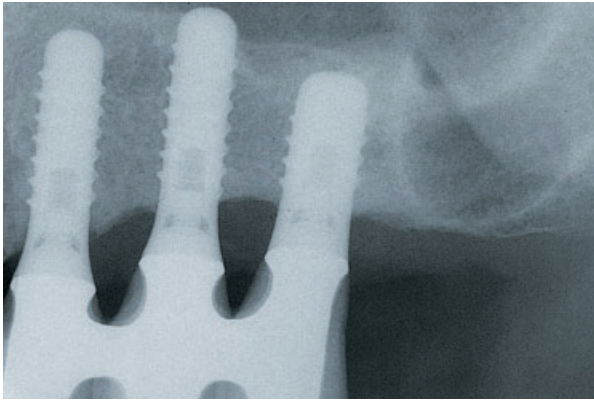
The 4-year follow-up radiograph confirms stable conditions at the osseointegrated interface.
